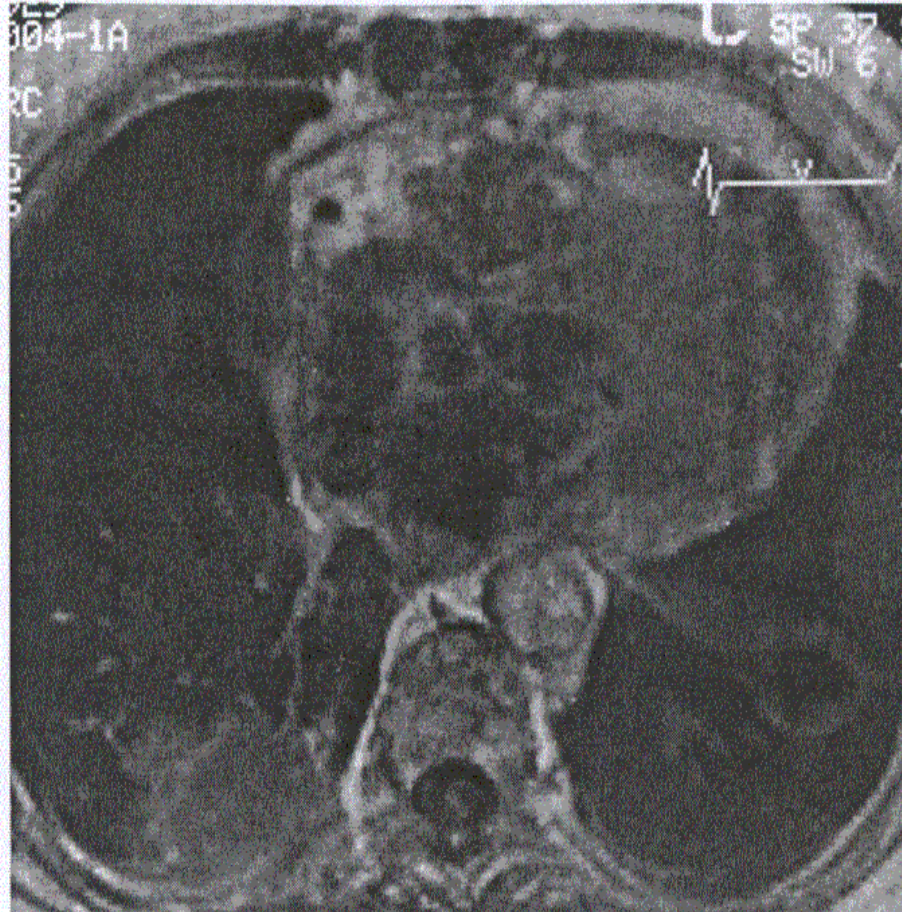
Transversal T1-weighted image after end-diastolic injection of gadolinium. The primary lung tumour is in the right lobe, and the heart metastasis is located in the wall of the left ventricle, with tumoural infiltration of the pulmonary artery
